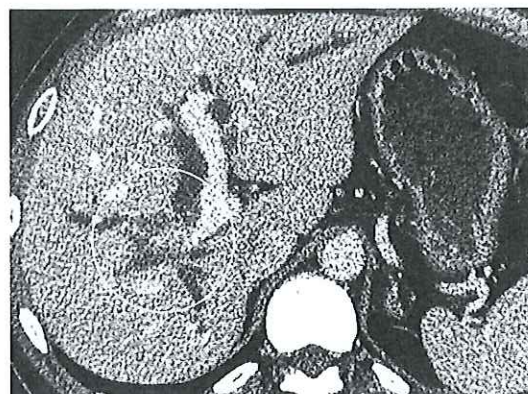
腹部造影 CT 所見：左右肝管合流部から三管合流部にかけて、造影効果をともなう壁の不整な肥厚と内腔狭窄を認めた。門脈右枝の狭窄を認めた。
